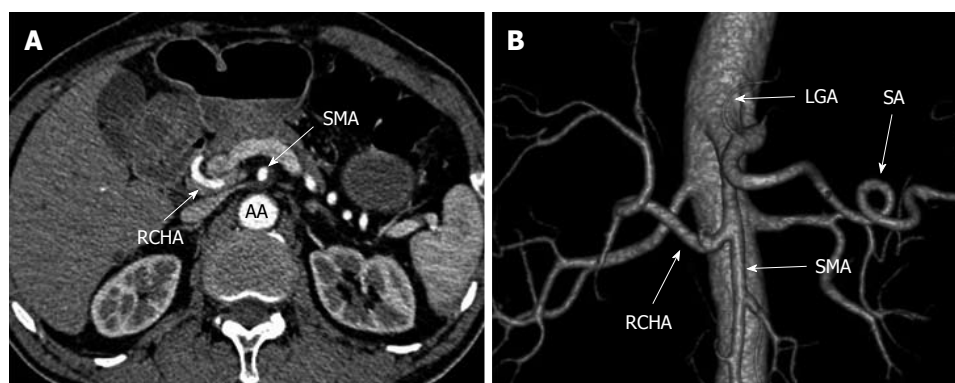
Sixty-eight-year-old man with a replaced common hepatic artery. A: MDCT demonstrating an RCHA originating from the SMA, running behind the superior mesenteric vein, with no common hepatic artery found arising from the celiac axis; B: Volumetric three-dimensional CT angiography demonstrating Michels type IX. RCHA: Replaced common hepatic artery; MDCT: Multidetector computed tomography; CT: Computed tomography; SMA: Superior mesenteric artery; SA: Splenic artery; LGA: Left gastric artery; AA: Abdominal aorta.
